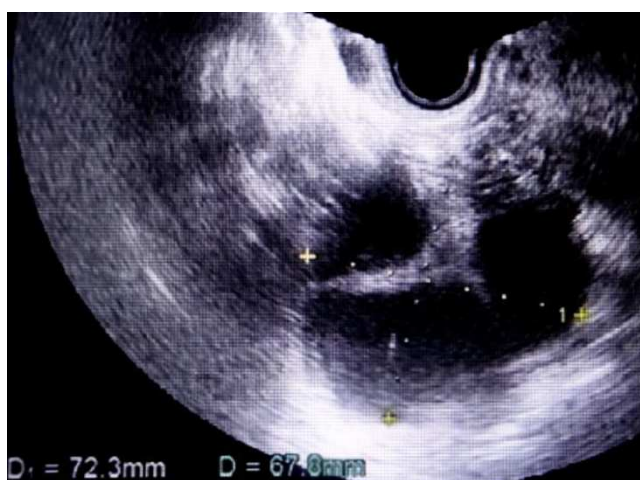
Transvaginal ultrasound images showing markedly enlarged polycystic ovaries. The right ovary measured 72.3 × 67.8 mm.
